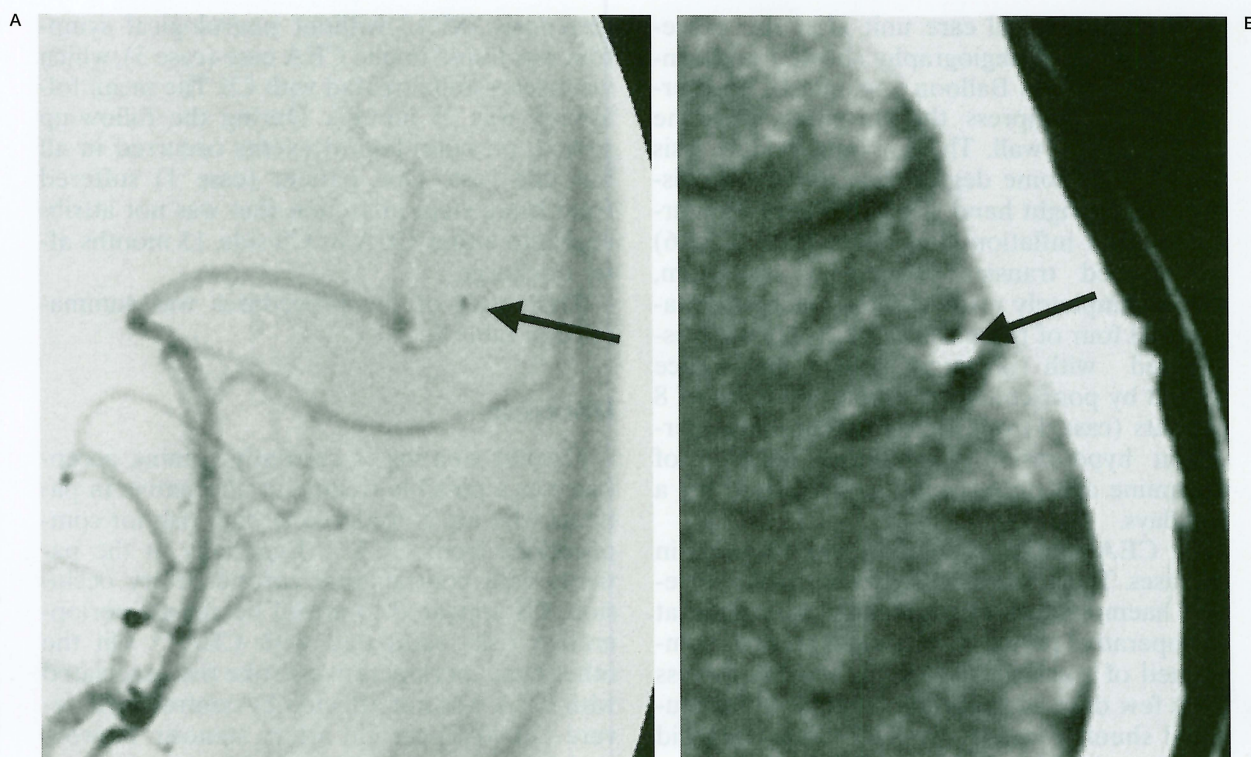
A) Angiography of the patient (case 2) in whom protective balloon ruptured during the post-dilation. The fragment of the ruptured balloon (arrow) was migrated into left precentral artery. B) The fragment of the balloon was visualized as a high density spot (arrow) in the left frontal lobe in the computed tomographic scan.
